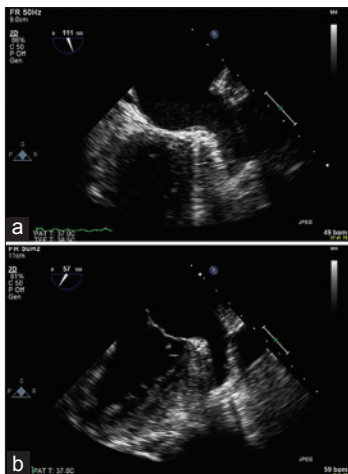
(Video 1 & 2). Pre- and post-transcatheter aortic valve replacement (TAVR) transesophageal echocardiogram (TEE) showing dense spontaneous echogenic contrast (SEC) in the left atrium and left atrial appendage (LAA). (a, Video 1) Pre-TAVR TEE showing LAA with SEC. (b, Video 2) Post-TAVR TEE showing LAA without SEC.
